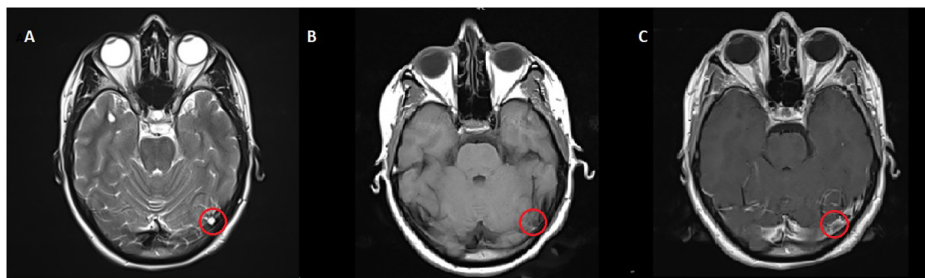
In the axial T2WI (A), a hyperintense lesion is seen in the left transverse sinus. The lesion shows no enhancement on pre- (B) and post-contrast (C) T1WIs. T1WI, T1-weighted image; T2WI, T2-weighted image.
